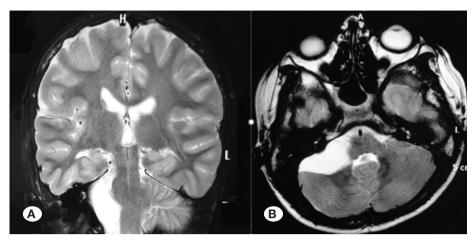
A coronal T2-weighted MRI scan showing AC with brain stem compression (A). Axial T2-weighted MRI scan showing an AC located in the right cerebellopontine angle (B).
